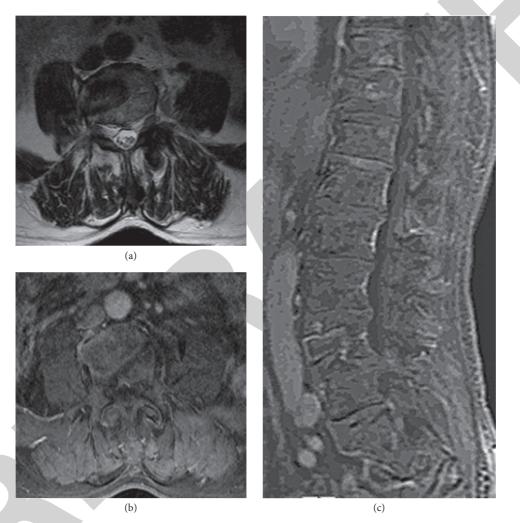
MRI image of hemangioma. (a, b) DE-MRI showing angiography of hemangioma; (c) nodule changes in lesions; (d) filler angiography of advanced hemangioma.
